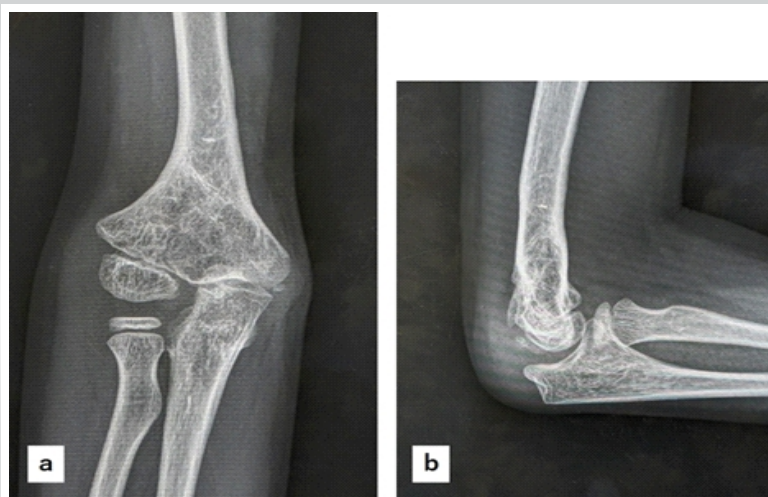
X-ray findings at final follow up. (a): Anteroposterior view, (b): Lateral view.
